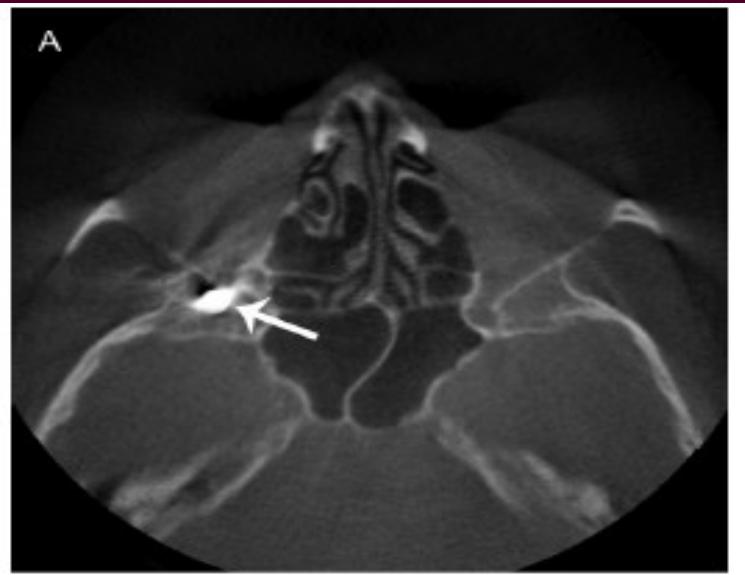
Transverse CBCT (A) and CT (B) scans of a (Flobert-type) lead round nose bullet (arrow) lodged lateral to the temporal bone.
